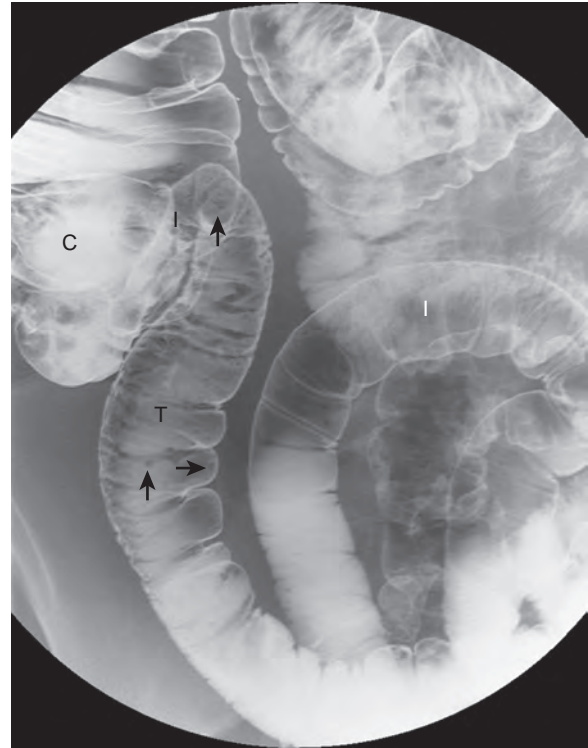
Normal distal ileum demonstrated during peroral pneumocolon (arrows). Spot radiograph shows the terminal ileum (T) and distal ileum (white I) in an air-contrast study. The mucosa is smooth and featureless. The ileal folds (arrows) are of normal thickness. The cecum (C) and ileal side of the ileocecal valve (black I) are also identified.
